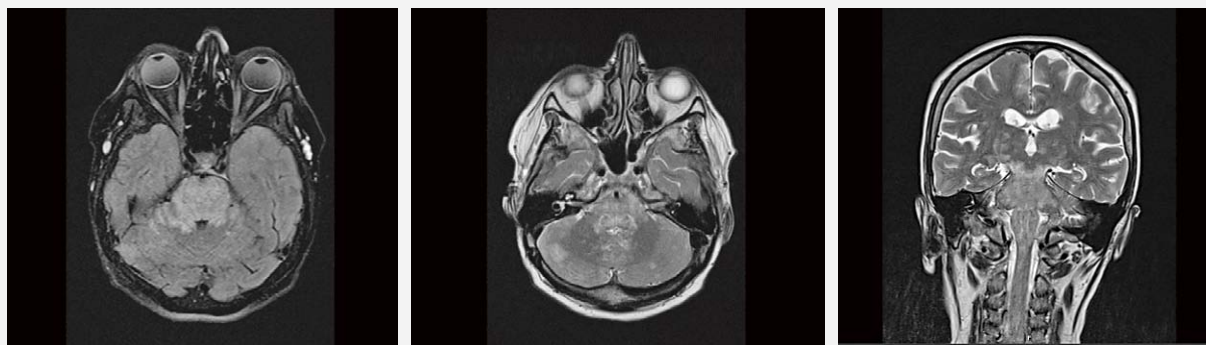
Brain MRI of a 59-year-old hypertensive female patient with renal impairment showing typical hyperintense changes in brain stem and in cerebellar both hemispheres on T2/FLAIR sequences.
